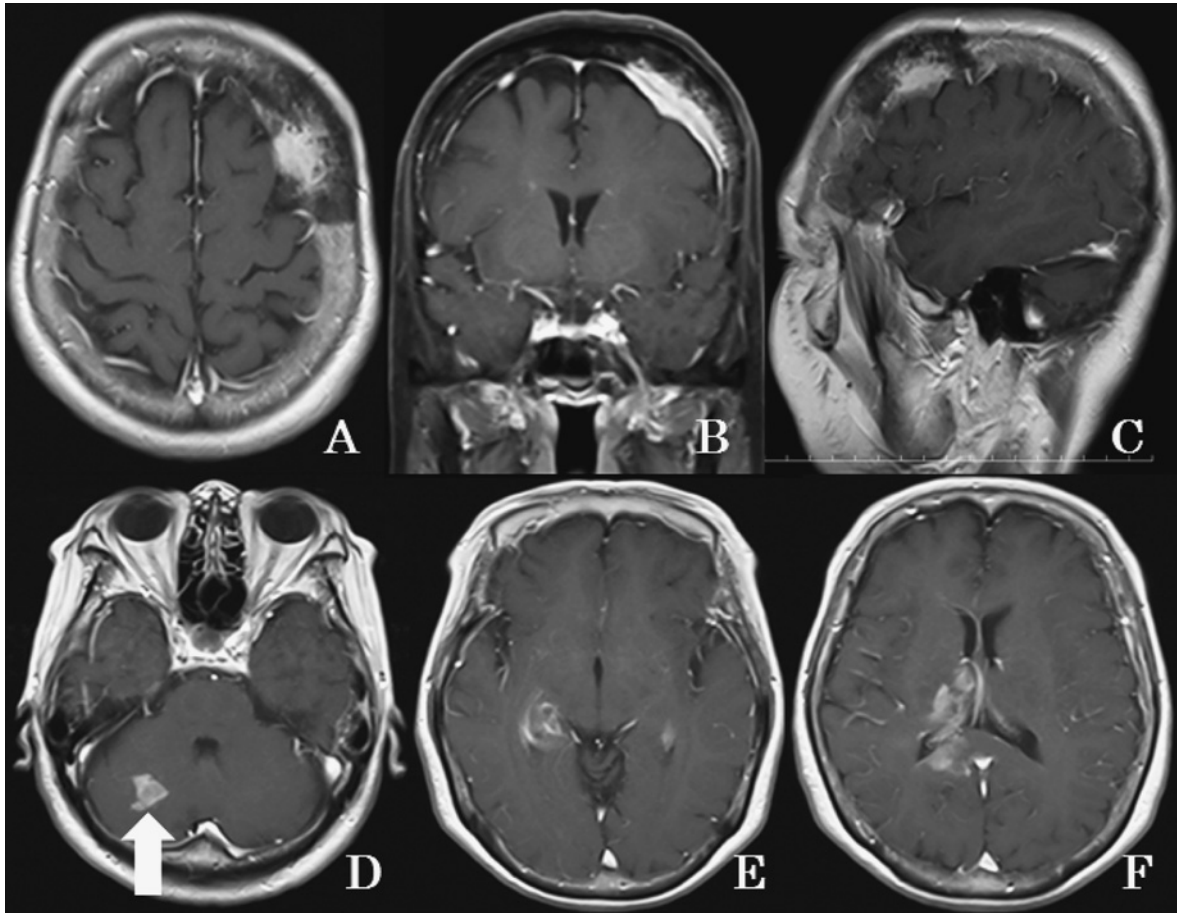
Gadolinium (Gd)-enhanced magnetic resonance (MR) images obtained on the 9th day after onset MR image showing multiple enhanced brain lesions, including the skull tumor (A-F). B shows only fat suppression.
